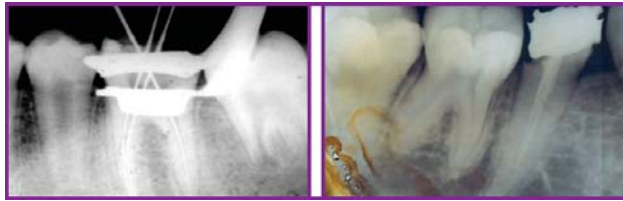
Quality of radiographs, good quality Vs poor quality
